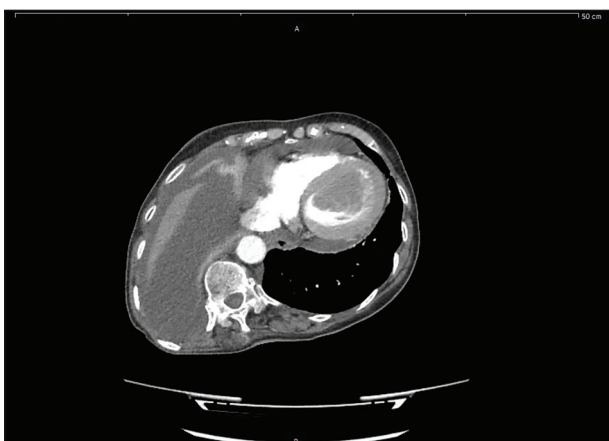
Computed tomography (CT) scan of thorax showing mass in the left ventricular cavity
